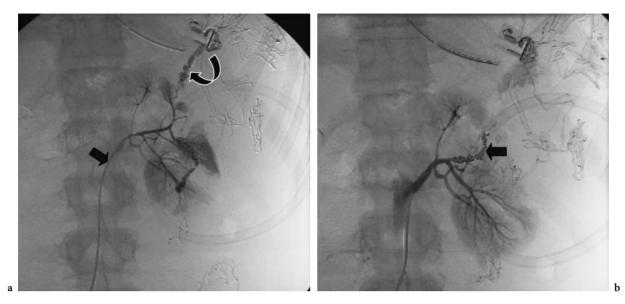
a A 17-year-old boy who was involved in a motor vehicle accident. At presentation at the emergency department, ultrasound imaging showed free fluid surrounding the left kidney. Computed tomography revealed a left renal laceration. The ensuing selective renal angiography (*arrow* denotes the angiography catheter) clearly demonstrates contrast extravasation (*curved arrow*). b After embolization with multiple coils no contrast extravasation was seen thus preserving renal function
